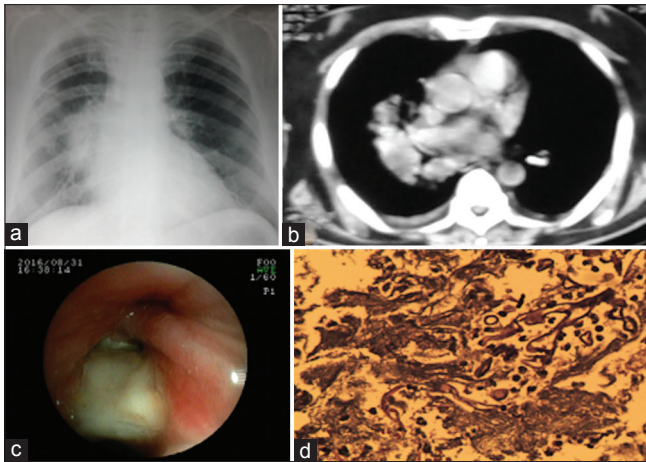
(a) X-ray chest showing right parahilar opacity, (b) contrast-enhanced computer tomography chest showing right hilar mass compressing intermediate bronchus, (c) fiber-optic bronchoscopy showing thick whitish necrotic material filling right intermediate and lower lobe bronchi, (d) bronchial biopsy showing aseptate acutely branching hyphae suggestive of mucormycosis
